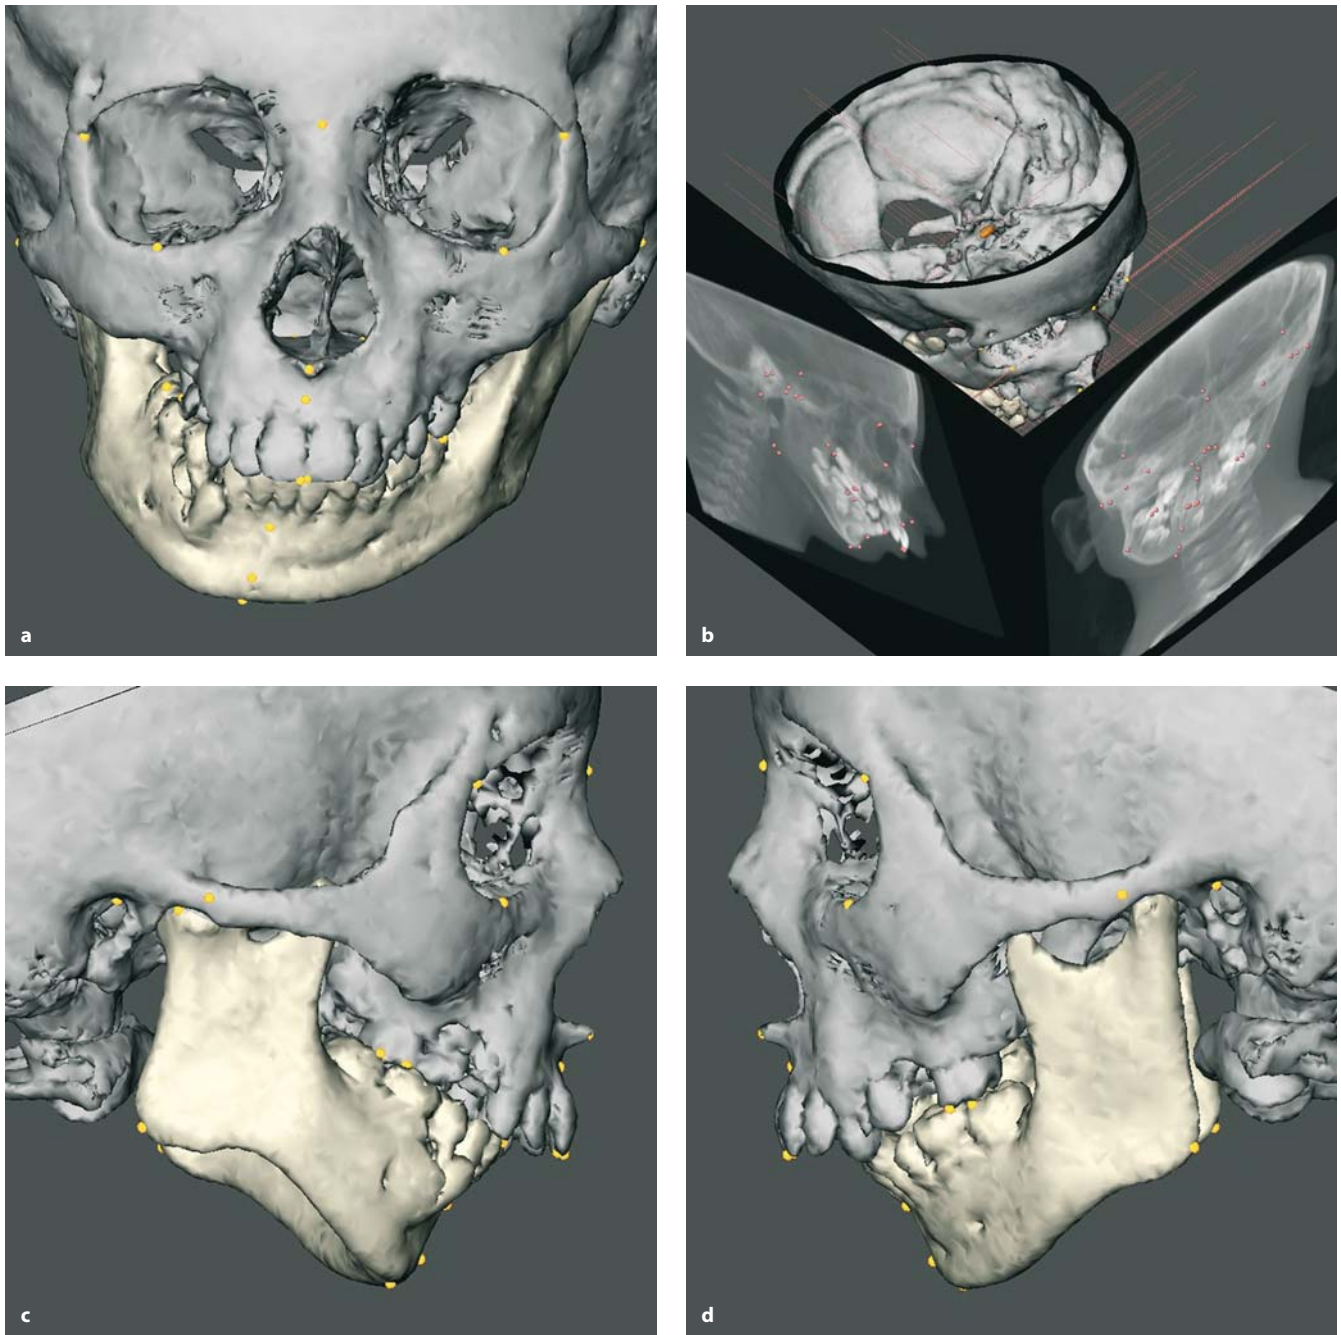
a–d. Pre-operative 3-D CT hard tissue surface representations with set-up of 3-D cephalometric hard tissue landmarks. a Frontal view; b linked lateral and frontal virtual cephalograms; c profile view right; d profile view left. (3-D CT, patient B.R.)
